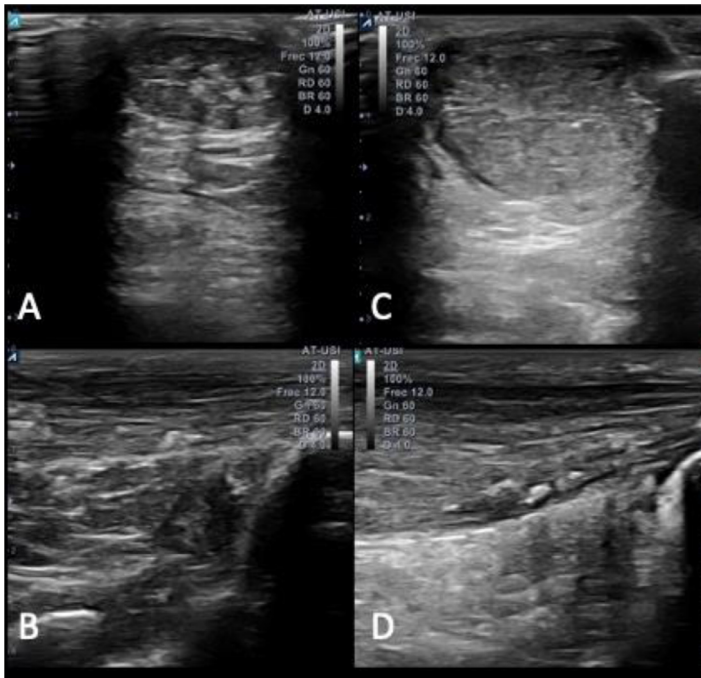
Ultrasound imaging of a healthy Achilles tendon -transversal (A) and a longitudinal view (B) – and an Achilles tendinopathy tendon – transversal (C) and longitudinal view (D).
